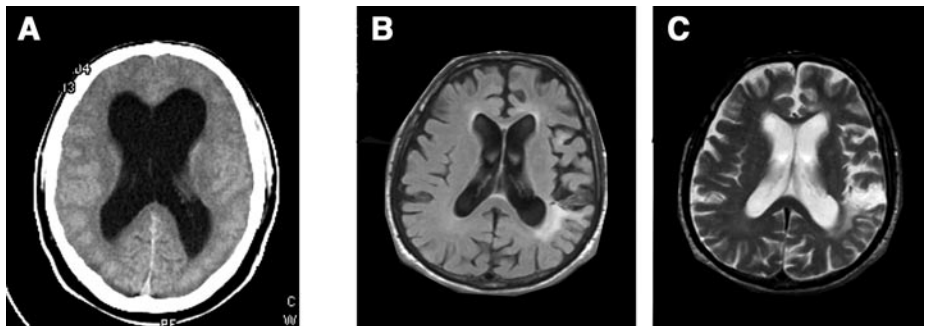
Examples of ventriculomegaly, a hallmark of chronic hydrocephalus, with cortical effacement as seen on CT (A), and cortical atrophy observed on T1 and T2 MRI (B, C).
